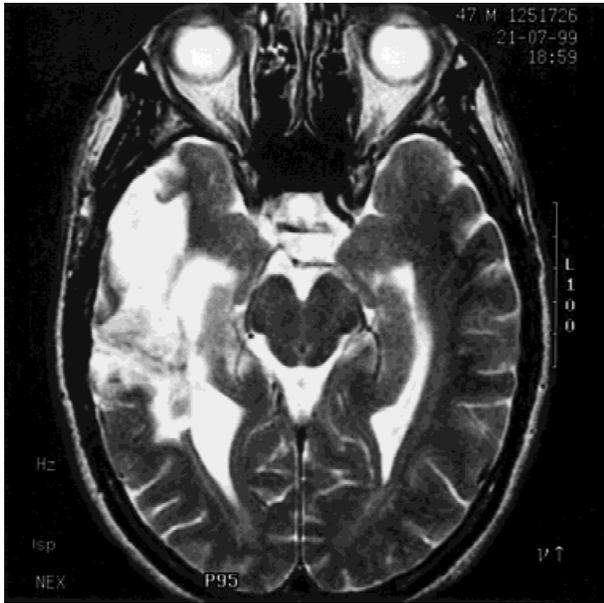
Magnetic resonance imaging scan of the brain (T2 weighted) showing hyperintense signal of the right temporal lobe in the area of previous intracerebral haemorrhage. There was no mass lesion, hydrocephalus, or abnormality in the midbrain or basal ganglia.
